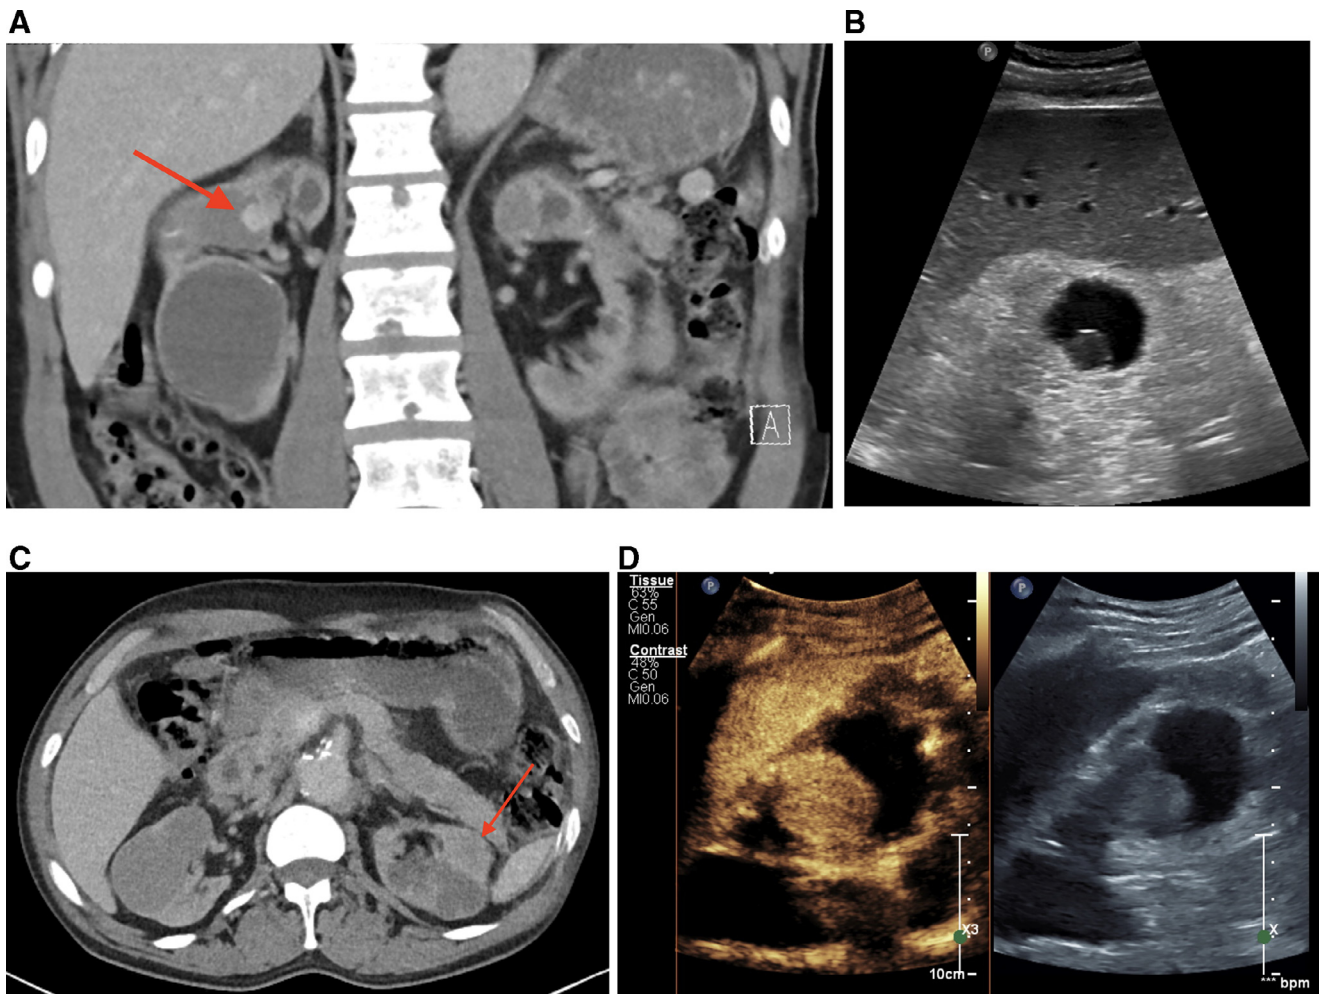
A 57-year-old male on long-term peritoneal dialysis. Both kidneys were atrophic and contained bilateral cysts in keeping with acquired cystic kidney disease. (a) Coronal portal venous phase CT scan shows an enhancing 1.2 cm mural nodule in a right upper pole cyst. (b) The nodule within the cyst is clearly demonstrated on US and has acute margins with the cyst wall in keeping with a Bosniak IV lesion. (c,d) CT and CEUS showed a 2.0 cm avidly enhancing nodule within a left interpolar region cyst, which washed-out after 20 seconds. Following nephrectomy, this was confirmed to be a Type 1 papillary RCC. The right-sided lesion is awaiting surgical management.
